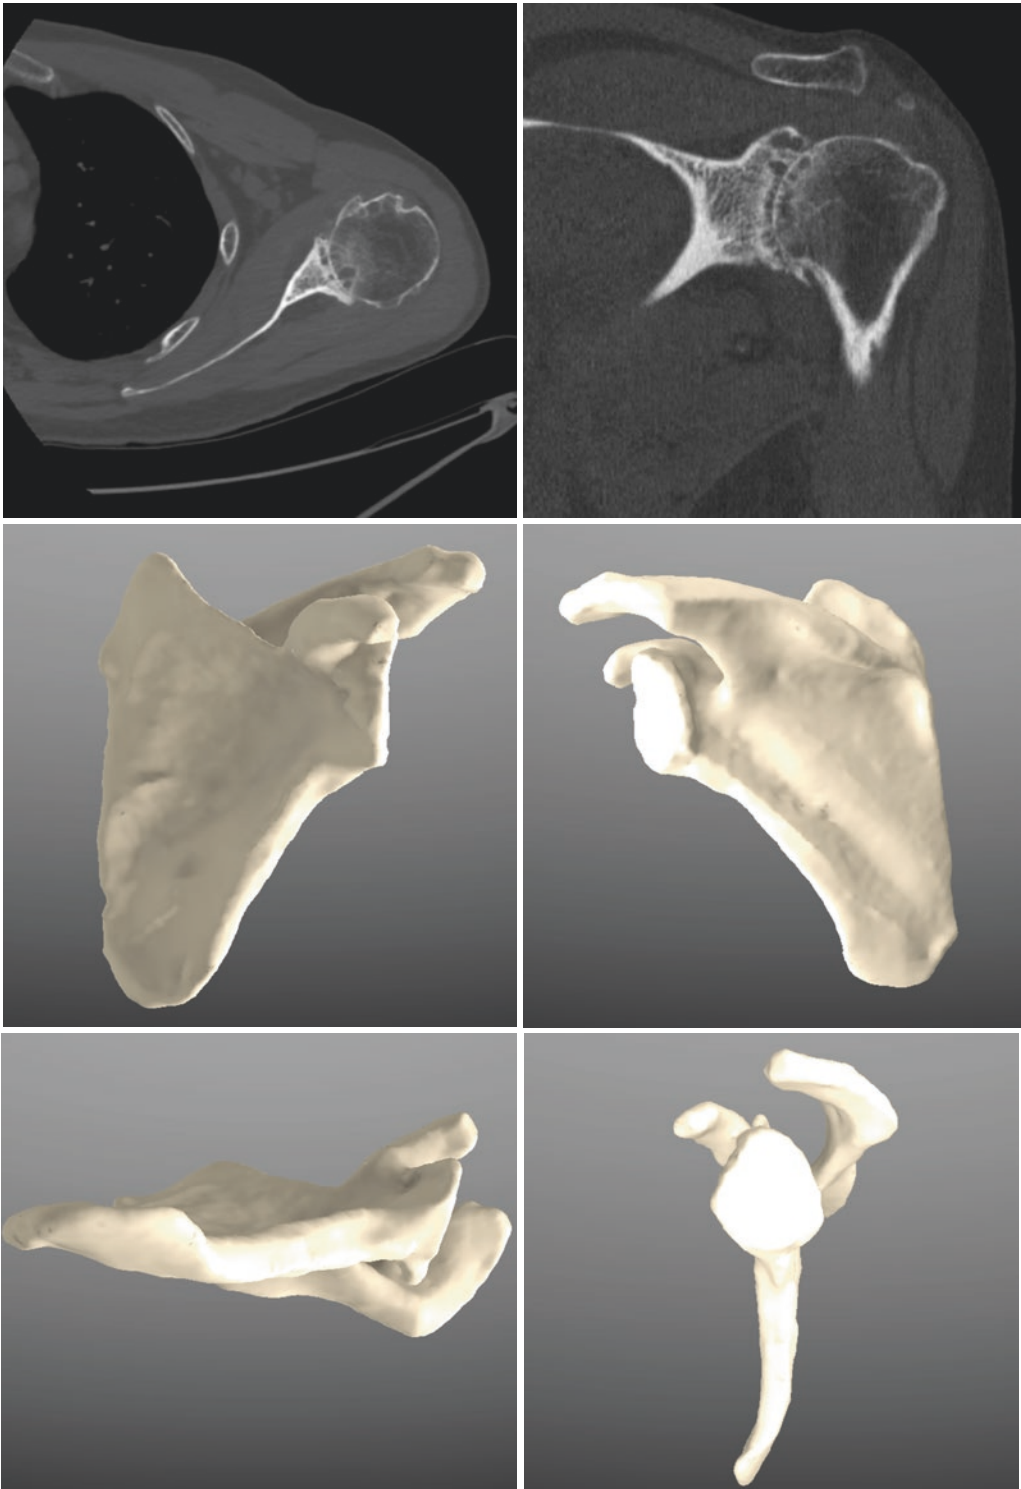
Preoperative 2D CT and 3D reconstructions demonstrating a glenoid retroversion of 14 degrees, with minimal posterior head subluxation
